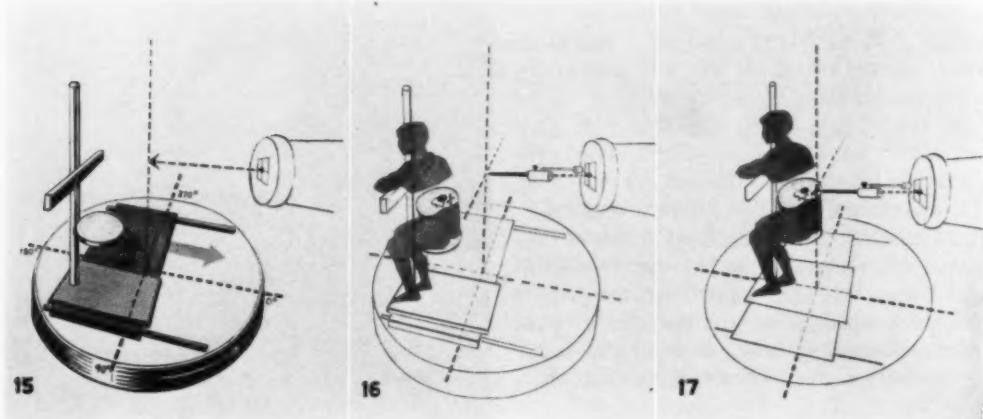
The platform is turned to the zero position. Its horizontal supporting cross-bars are perpendicular to the x-ray beam. The cross-bars move only in directions perpendicular and parallel to the x-ray beams.
